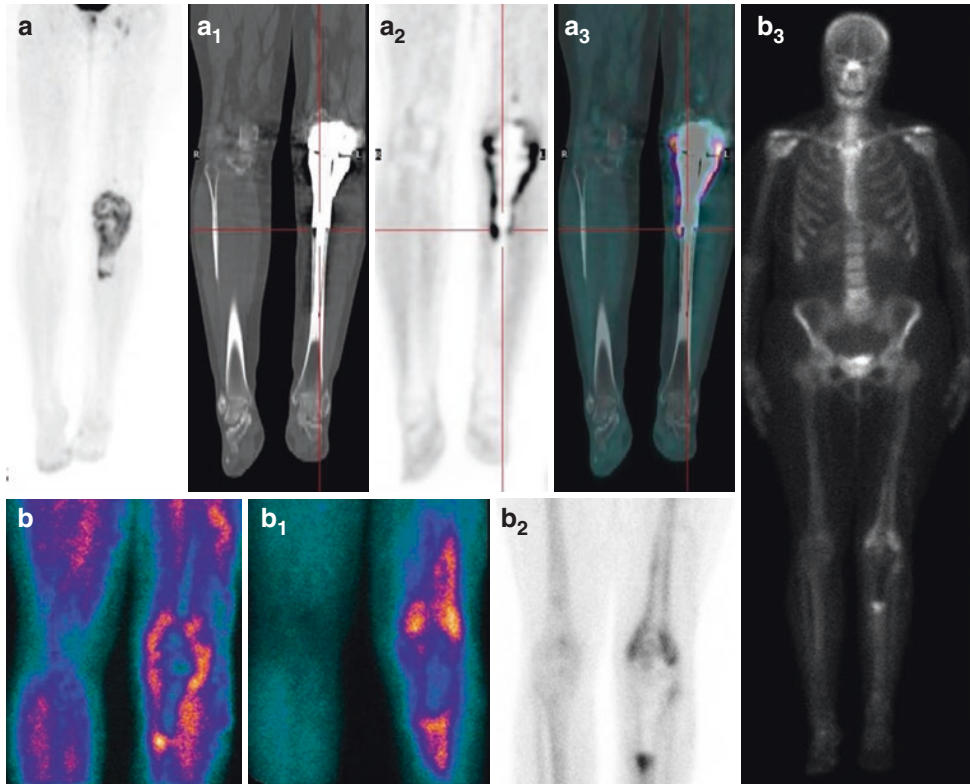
¹⁸F-FDG PET 3D maximum intensity projection (a), coronal CT (a₁), PET (a₂), and PET/CT (a₃) views show intense pathologic tracer uptake surrounding a prosthesis of the left knee. Triphasic planar scintigraphy with ^{99m}Tc-labeled leukocytes (b, b₁, b₂, and b₃) confirms
